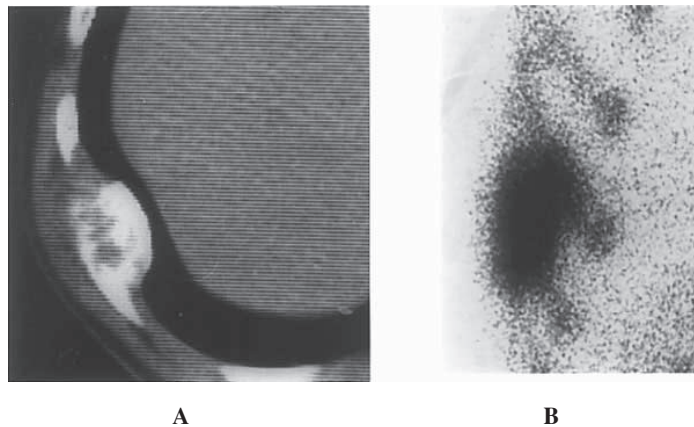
Dedifferentiated chondrosarcoma (21-year-old man). A: CT. There is a densely ossified mass. No significant soft tissue density component is noted. B: Bone scintigraphy. Tumor uptake is significant.
